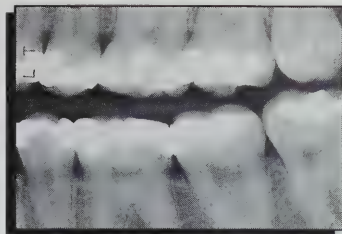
Case 4, bitewing radiograph taken three months before the episode of barodontalgia. Tooth 27 demonstrates a mesio-occlusal restoration and a diffuse radiolucency near the distal part of the restoration. On clinical examination, this tooth displayed extensive buccal and distal caries and was the source of the painful episode during flight.
